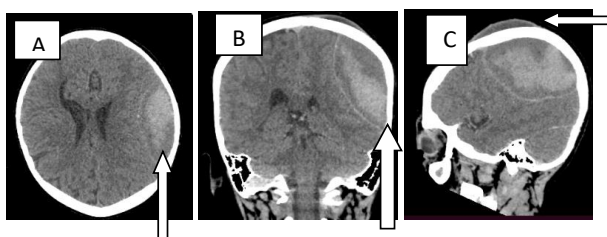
Non-contrast cranial axial (A) and coronal (B) CT scan showing right parietal extradural hematoma, the sagittal view (C) showed overlying subgaleal hematoma).
